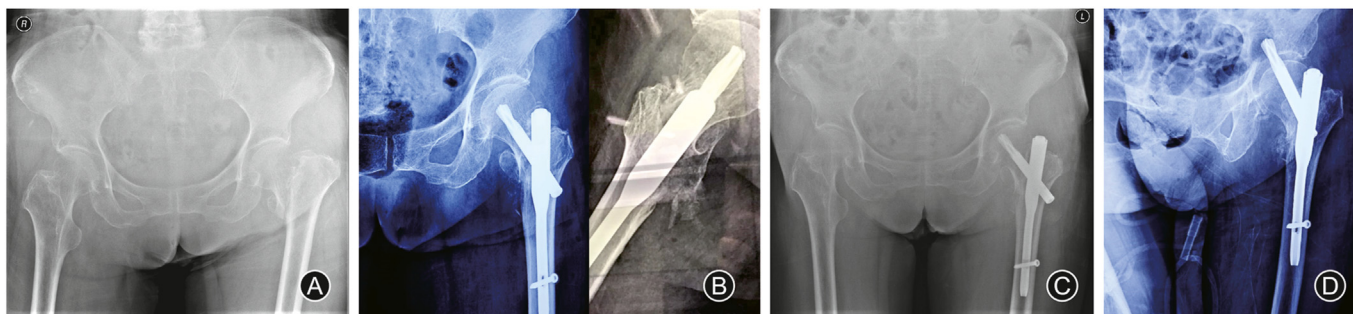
(A) Initial X-ray showing an intertrochanteric fracture of the left hip (AO/OTA classification 31-A2.2); (B) Post-operative anteroposterior and lateral X-rays of the fracture treated with proximal femoral nail anti-rotation; (C) Anteroposterior X-ray at 4 weeks after surgery showing medial migration of the helical blade; (D) Anteroposterior X-ray at 8 weeks after surgery showing perforation of the helical blade into the acetabulum.
